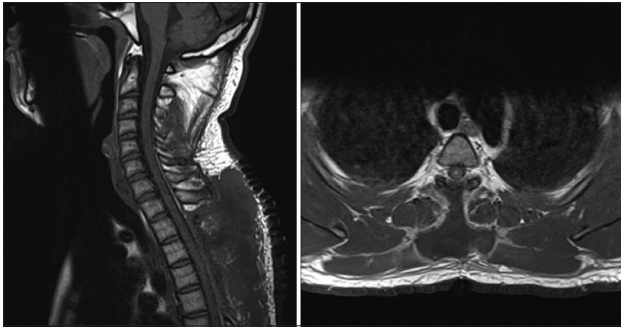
Immediate postoperative MRI, showing laminectomy of D3 to D5, with apparent gross total removal of the medullary granuloma (T1-weighted, sagittal, and axial)
